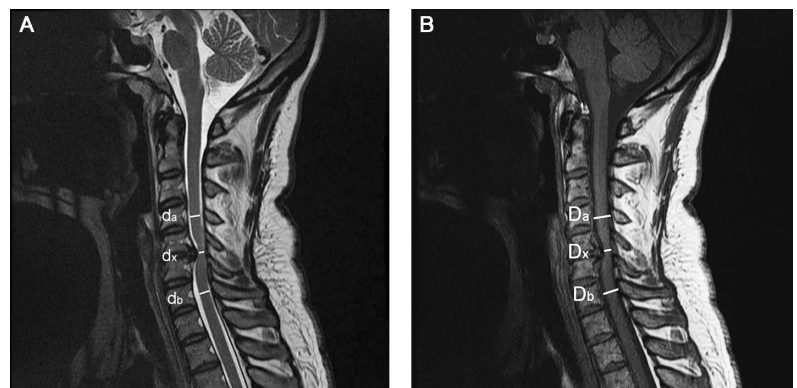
(A) Measurements for the maximum spinal cord compression using midsagittal T2-weighted magnetic resonance imaging (MRI). (B) Maximum canal compromise using midsagittal T1-weighted MRI.
